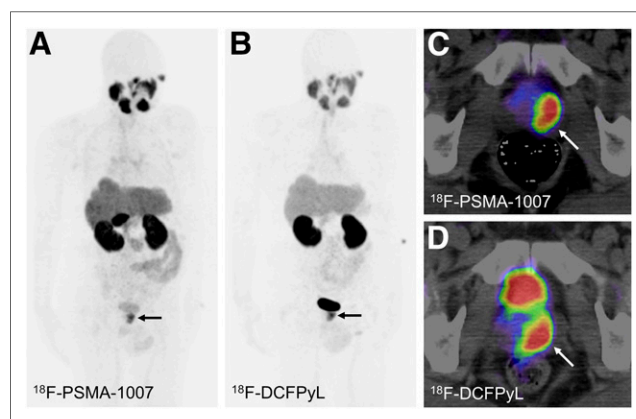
PET/CT images of 80-y-old patient with newly diagnosed prostate cancer referred because of PSA serum level of 95.43 ng/mL and positive biopsy (Gleason score 8 [4 + 4]). Patient was examined with ¹⁸F-DCFPyL (B and D) in May 2017. Second examination with ¹⁸F-PSMA-1007 followed 48 h later (A and C). Diagnosis of prostate cancer confined to prostate gland (arrows) was possible with both tracers. SUV_{max} in this lesion was 18.08 and 11.77 for ¹⁸F-DCFPyL and ¹⁸F-PSMA-1007, respectively.
